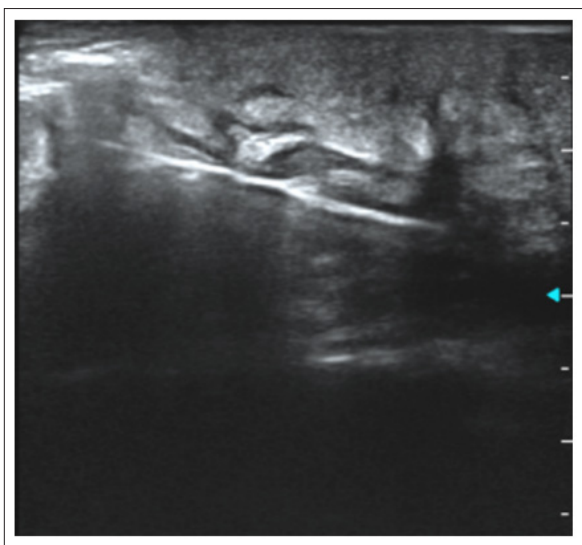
Ultrasound-guided biopsy of a breast mass. The image shows the biopsy needle crossing the target mass under ultrasound guidance, ensuring optimal precision for tissue sampling.
